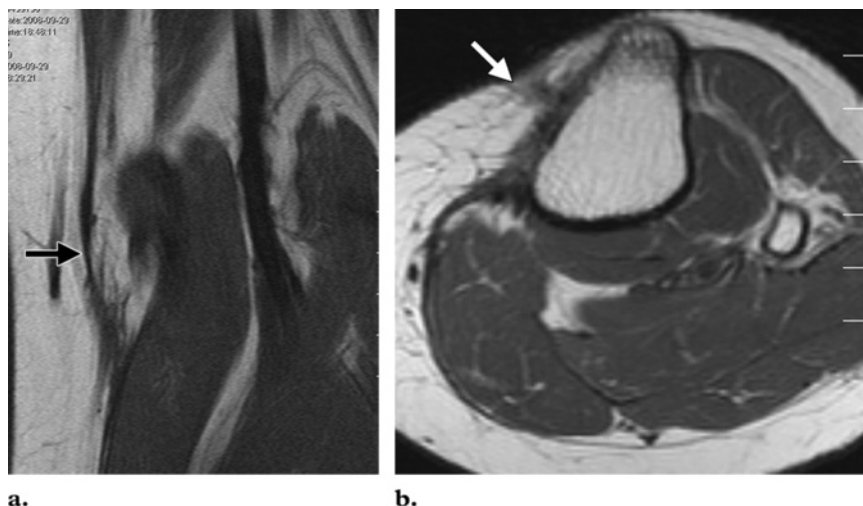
Hamstring graft harvesting site. (a) Coronal T1-weighted MR image shows scarring of the fat planes surrounding the distal semitendinosus tendon (arrow). (b) Axial proton-density–weighted MR image shows scarring around the insertion of the pes anserinus into the tibia (arrow).
